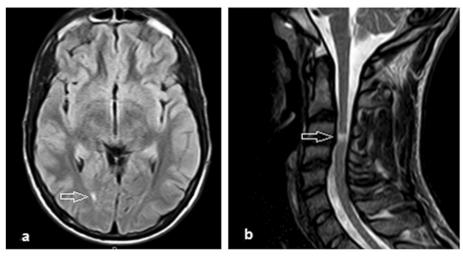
MRI demonstrates a axial FLAIR showing right occipital subcortical small area of signal alteration and b sagittal T2W showing cervical cord short segment of high T2W signal opposite to C3/4 disc
